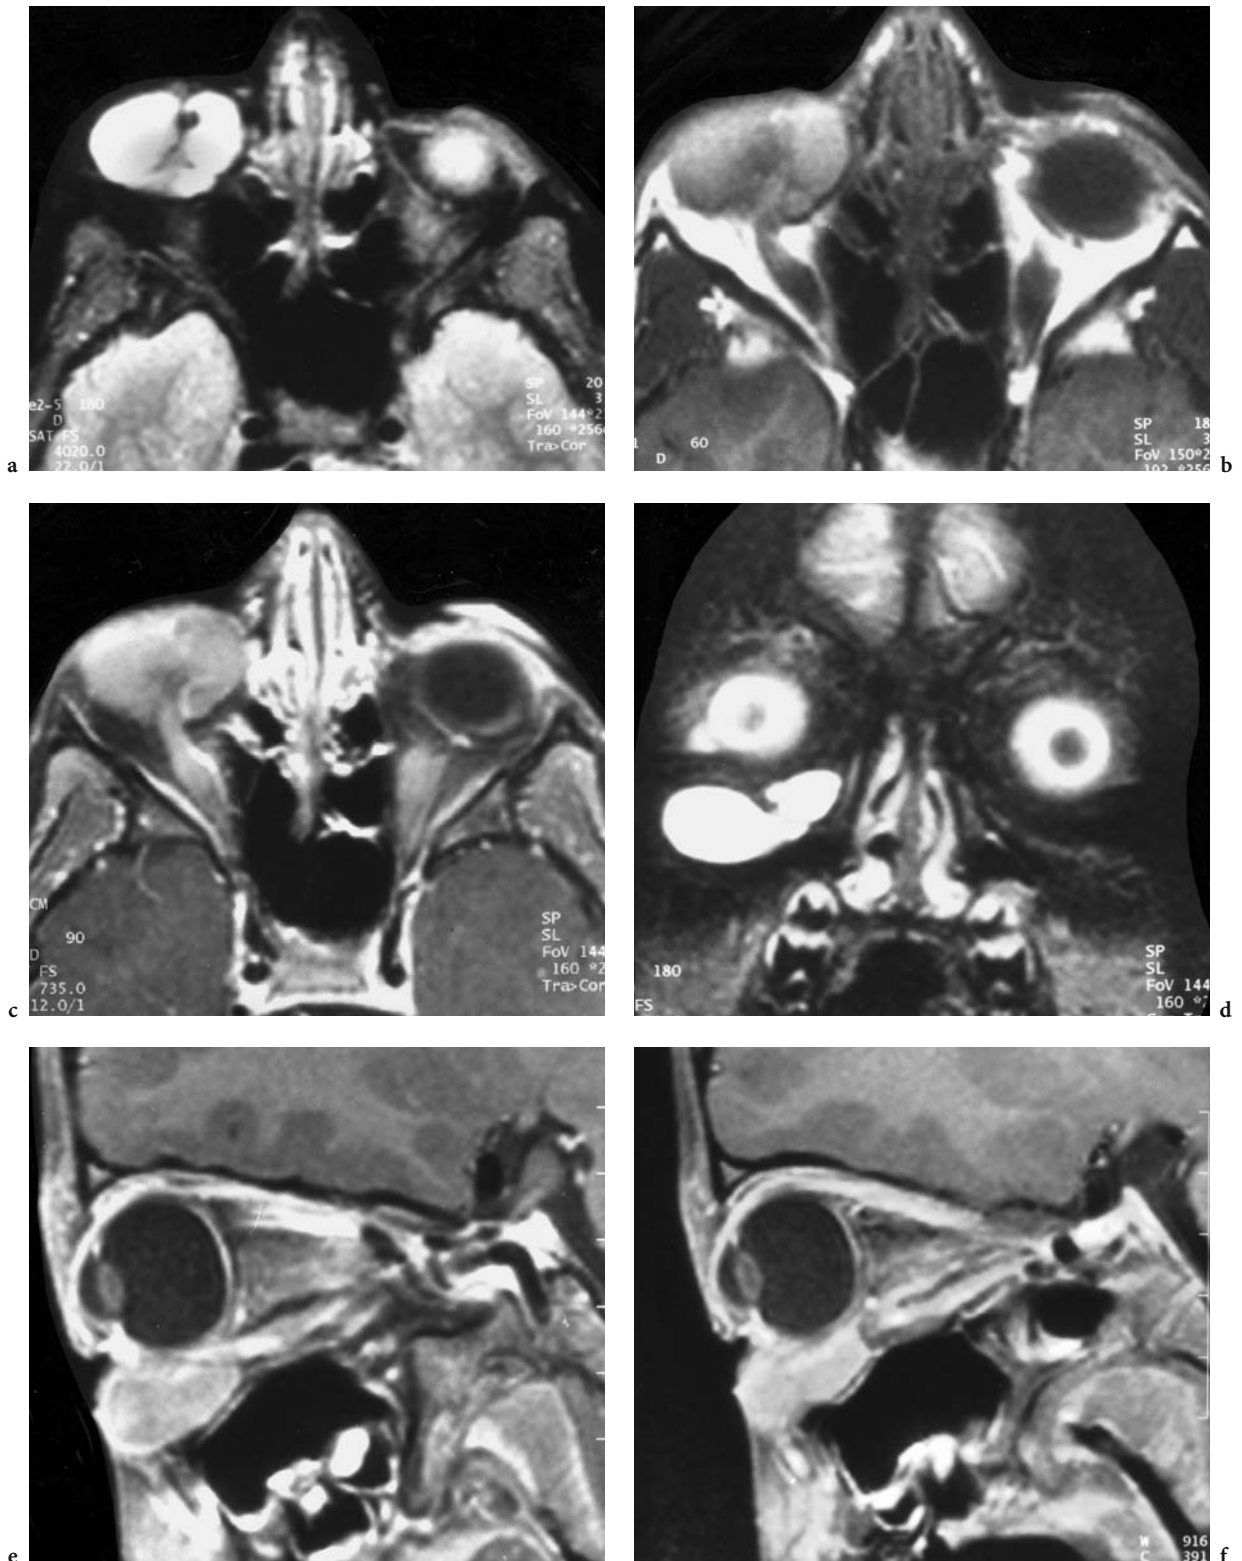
A 6-year-old boy with a livid, soft tumor of the inferior right lid. Diagnosis: hemangioma. MRI: a Axial T2-weighted image, showing a lobulated, hyperintense formation bilateral to the tendon of the right inferior rectus muscle. b Corresponding T1-weighted image, where the lesion presents with slightly hyperintense signal. c Corresponding contrast-enhanced (FS) image. d Coronal T2-weighted image demonstrating the fluid consistency of this formation. The septation is caused by the tendon of the inferior oblique muscle (confirmed by surgery). e Sagittal paramedian (lateral, f medial) T1-weighted, contrast-enhanced (FS) views with good differentiation of the malformation at the level of the inferior rectus muscle, but no definite delineation of the orbital septum
